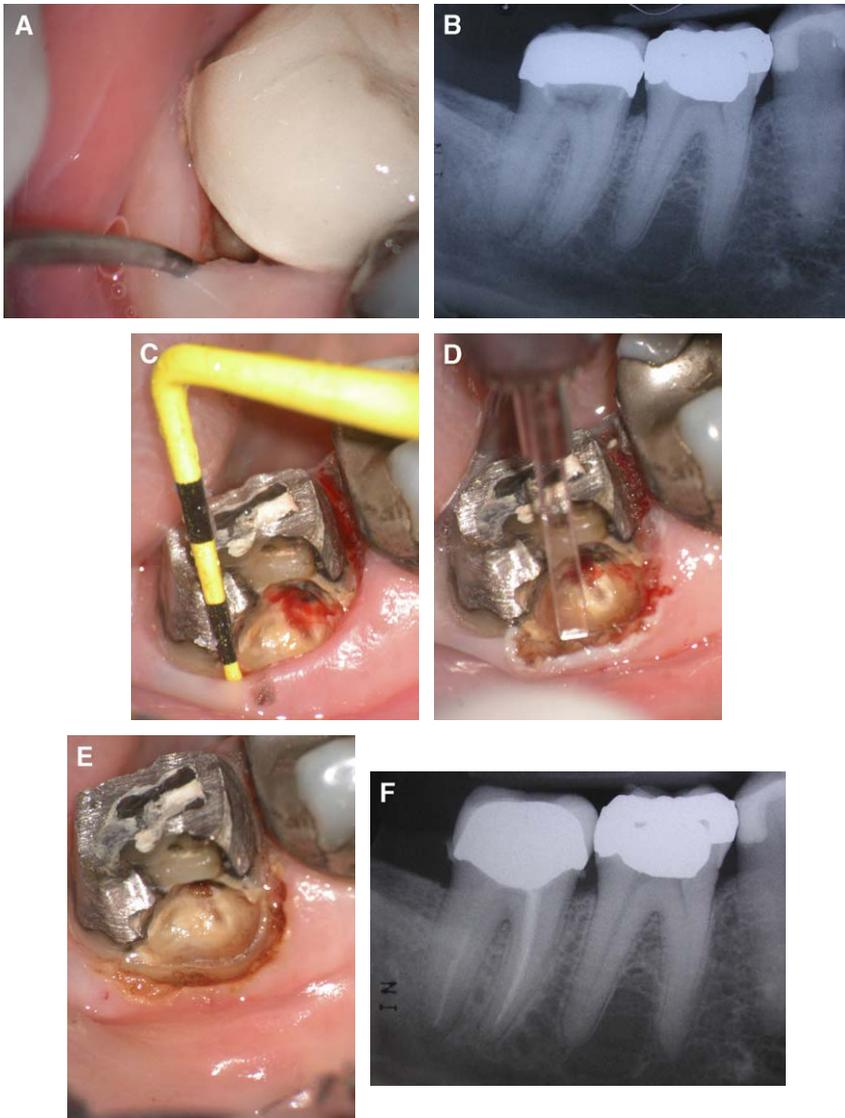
(A) Preoperative view of buccal caries. (B) Preoperative radiograph. (C) Periodontal probe showing inadequate biologic width after caries were excavated. Endodontic treatment was necessary due to pulpal exposure. (D) Erbium laser used to remove facial bone. (E) Osseous and soft tissue troughing completed. (F) Final restoration placed. (G) Radiograph of final restoration.
